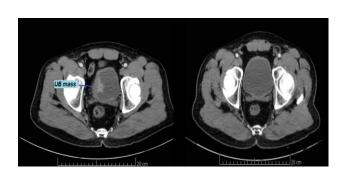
Post contrast CT before NAC and after post contrast CT after NAC revealing good response to neo adjuvant chemotherapy.
